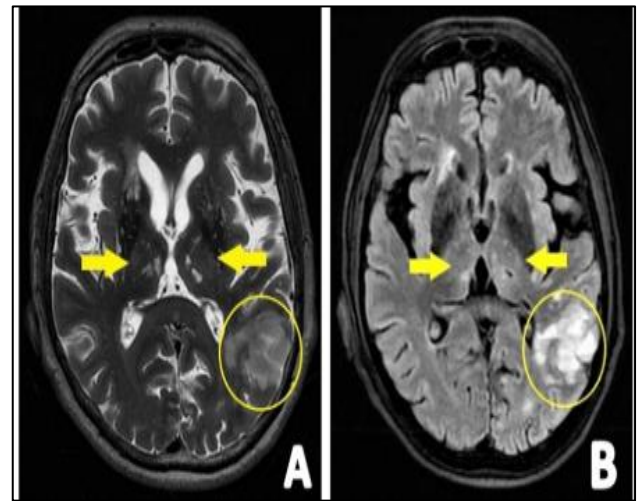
(A and B): Axial T2W and axial FLAIR images showing strategic infarctions in both thalami and in the parieto-occipital watershed area. Images were obtained in a male patient, age 71, with clinical manifestations of VaD. FLAIR: Three-dimensional T2-weighted fluid-attenuated inversion-recovery imaging.¹⁰
